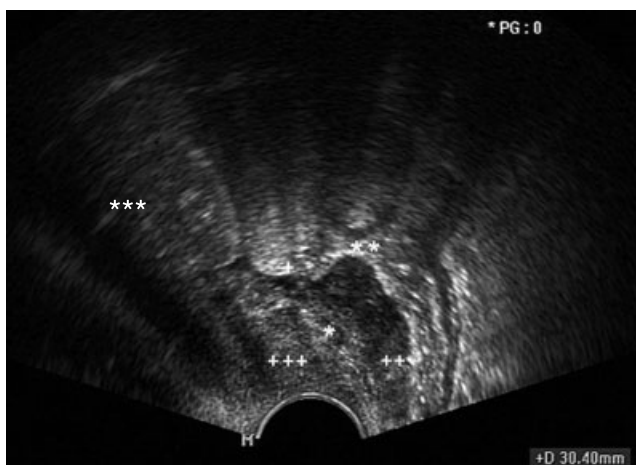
Transvaginal sonography showing a solid, partly cystic hypoechogenic nodule (++) situated posterior and inferior to the pouch of Douglas (+), partly infiltrating the posterior vaginal wall (*) and the anterior rectosigmoidal wall (), corresponding to deep infiltrating endometriosis of the rectovaginal space and rectosigmoid. +++, cervix; *, uterus.
